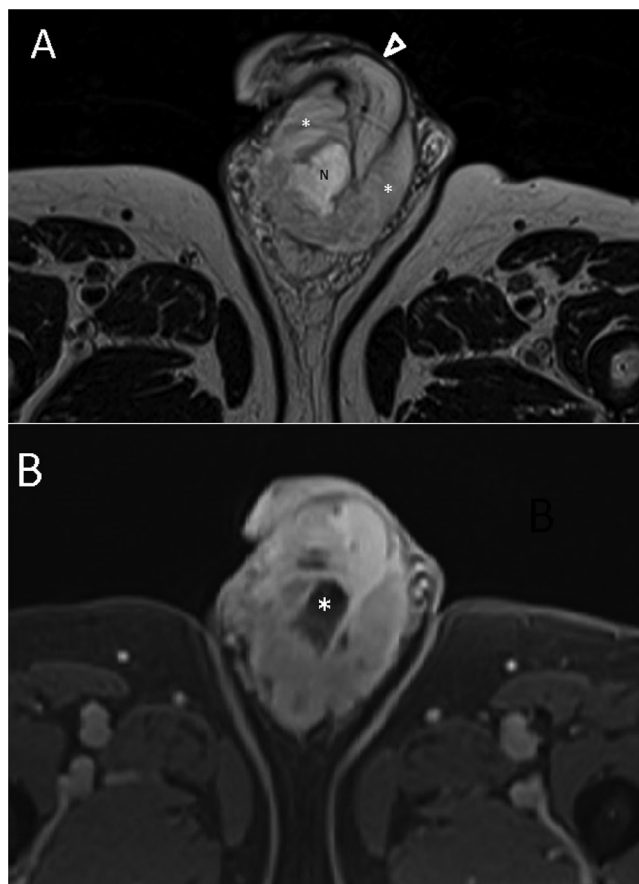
(A) Axial T2-weighted TSE and (B) gadolinium-enhanced T1-weighted fat-suppressed 3D-GRE imaging demonstrates a T2-hyperintense, avidly enhancing mass (* in A) with internal necrosis (N in A; * in B) and a rightward curved deformity of the penis (arrowhead in A). GRE = gradient echo.
